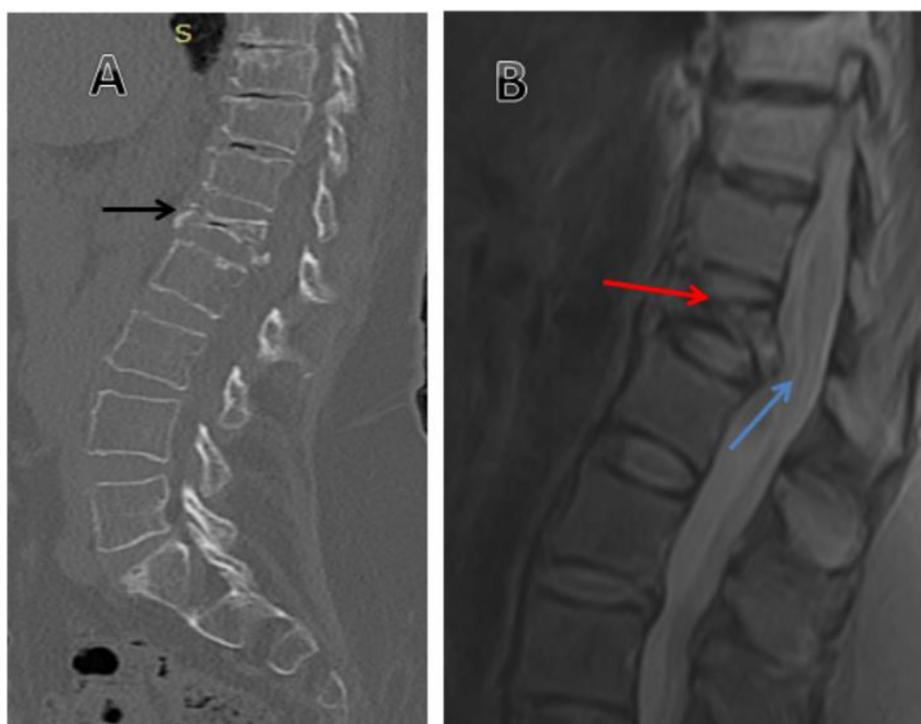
(a) CT scan of lumbar spine, sagittal view, bone window: shows insufficiency fracture of L1 vertebral body that is completely collapsed (black arrow), with diffuse decreased bone density. (b) MRI scan of the lumbar spine, sagittal view, STIR sequence: shows the previously mentioned collapsed vertebra (red arrow) and compression on the thecal sac with abnormally high signal (suggesting edema or contusion) (blue arrow). CT, computed tomography.
